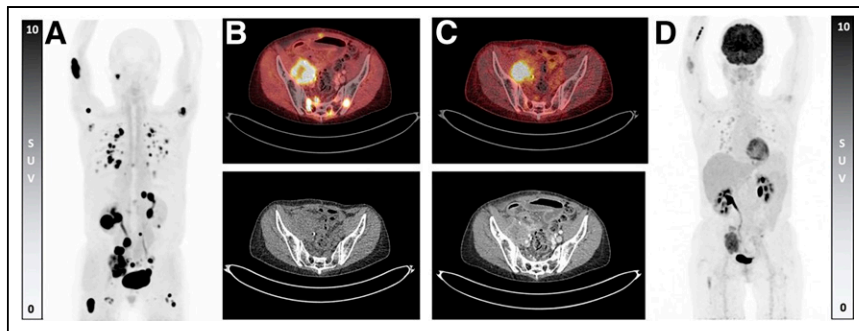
62-y-old patient with metastatic SFT. Higher ^{68}Ga -FAP uptake (A and B) than ^{18}F -FDG uptake (C and D) is shown in images of primary tumor in right pelvis (SUV_{max} of 25.1 in B vs. 9.0 in C) and multiple pelvic bone metastases (right sacrum, SUV_{max} of 23.0 in B vs. 2.2 in C). Shown are maximum-intensity projection PET images (A and D), axial PET images (B and C, top), and axial CT images (B and C, bottom).
